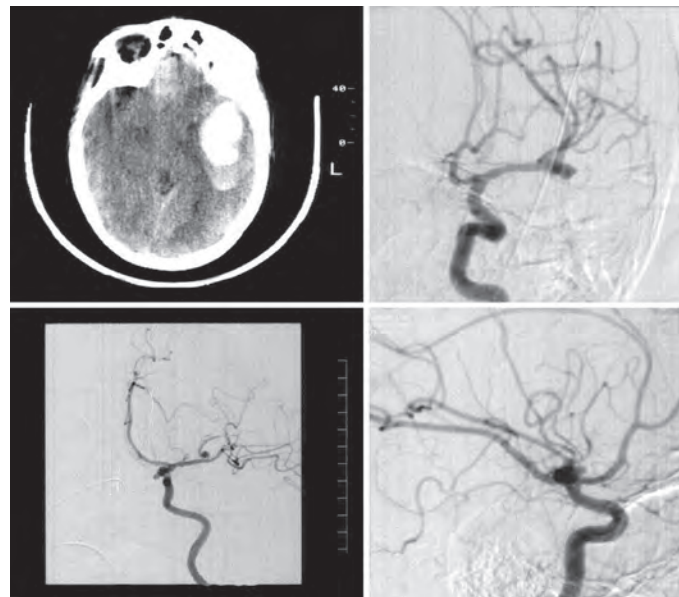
CT and DSA—Lt. temporal ICH and MCA bifurcation aneurysm
